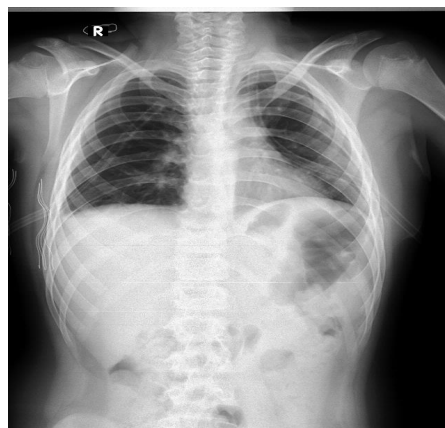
Posterior-anterior chest x-ray is showing lung expansion after tube drainage.
